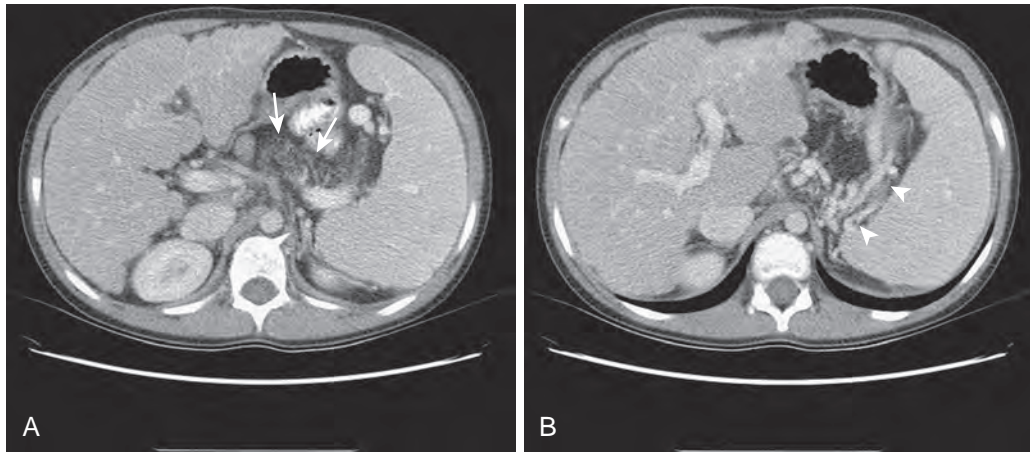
CT findings of the pancreas in cystic fibrosis. A and B. CT demonstrates fatty replacement of the pancreas (arrows) in a teenaged girl. The patient also has a nodular liver from hepatic fibrosis and has splenic varices (arrowheads) and splenomegaly from portal hypertension.
